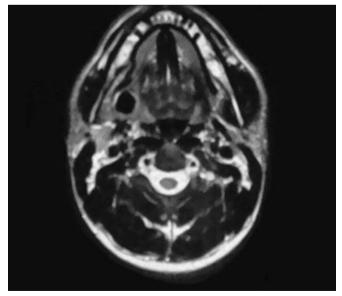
Axial MRI of the right submandibular gland.
